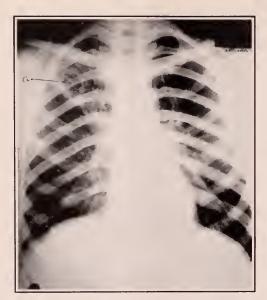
Case XIII. Roentgenogram of October, 1929, showing involvement in upper right lobe, with cavity formation (a). Left lung fields free from significant densities.
